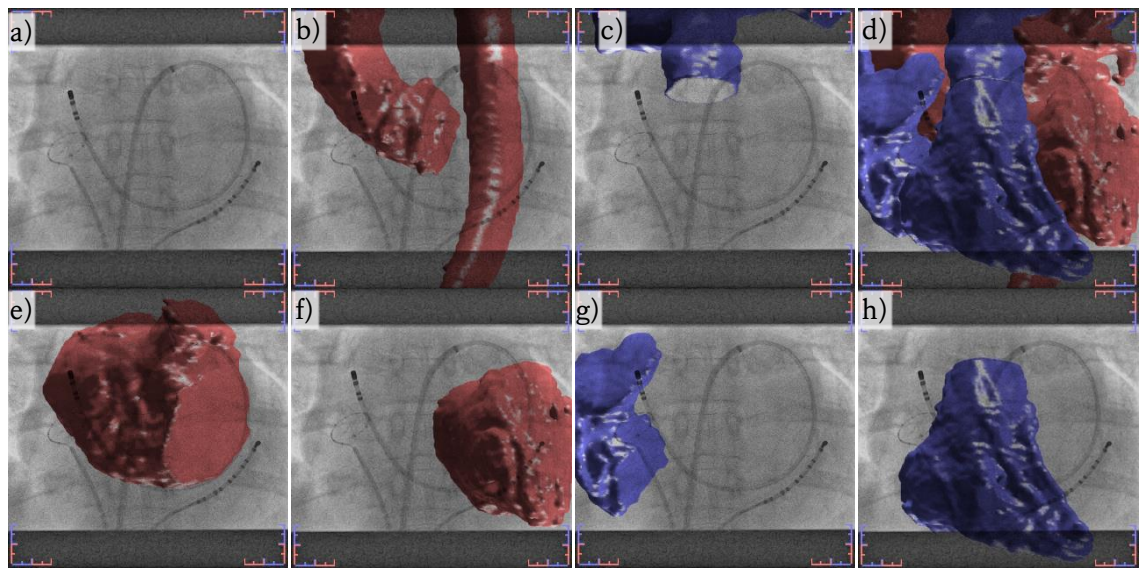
a) PA X-ray view of the patient’s heart with catheter loop inserted into the LA. Surface renderings of the heart segmented from the preoperative MR scan are overlaid onto the X-ray based on the looped-catheter-based 2×BNHC registration method. Parts of the heart overlaid are b) Ao (*red*), c) pulmonary artery (*blue*), d) WH (*red and blue*), e) LA (*red*), f) LV (*red*), g) RA (*blue*), h) RV (*blue*). Scales drawn at the corners of each image, representing 1-cm between each major tick, allow estimation of the overlay accuracy in terms of a mean and maximum 2D-TRE.
